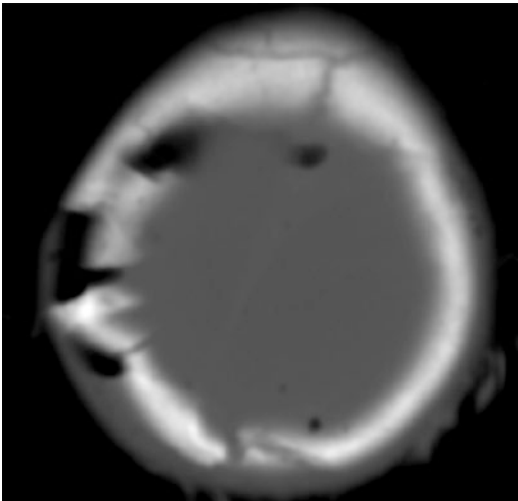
Axial head CT scan performed in a child victim of an air crash. Bone window allows to recognize the multiple head fractures and to differentiate them from the normal cranial sutures; pneumocephalus is also evident
